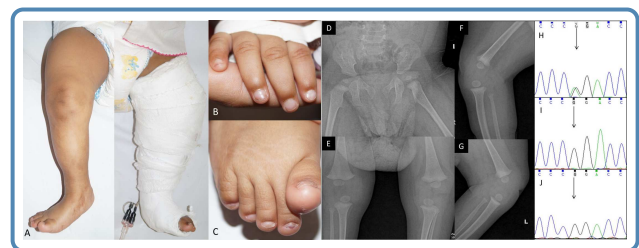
Clinical photographs of the patient showing skin dimpling due to the hypoplastic patella and cast application after tenotomy for congenital talipes equinovarus deformity of the left foot (A), and hypoplastic nails in the fingers (B) and toes (C). Radiographs showing bilateral iliac horns (D) and anteroposterior (E) and lateral view of knee joints (F and G). Electropherogram of exon 4 of *LMX1B* in the patient (H) showing the variant c.668G>A (indicated by black arrow) and electropherograms of the mother (I) and father (J) showing absence of this variant (indicating *de novo* occurrence of the variant).
